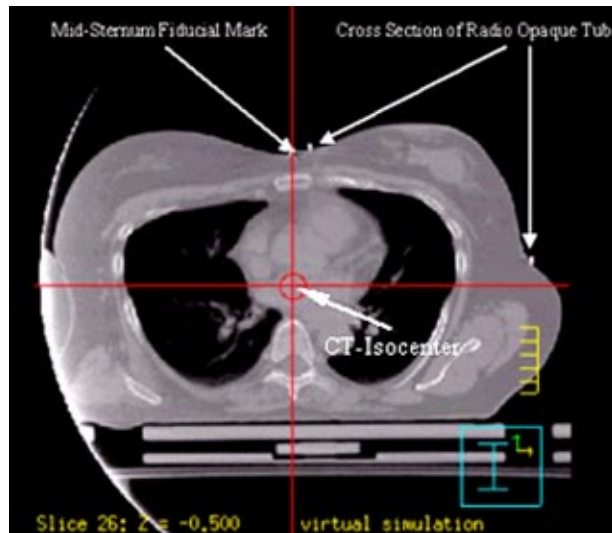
(Color) The CT-isocenter is placed at the intersection of the perpendicular through the anterior midsternum BB and the coronal plane passing through the BBs placed on the skin in the region of the lower axilla.
